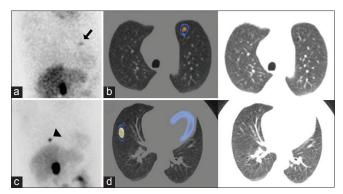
Rest single-photon emission computed tomography/computed tomography myocardial perfusion scintigraphy images showed a focal ^{99m}Tc-sestamibi accumulation in the anterior segment of the left upper lobe without any pulmonary pathology (arrow in [a] rest raw data image; [b] corresponding fusion lung window rest single-photon emission computed tomography/computed tomography and lung window computed tomography images). Stress single-photon emission computed tomography myocardial perfusion scintigraphy images revealed disappearance of the focal activity accumulation in the left lung and a focal uptake in the lateral segment of the right middle lobe with no pulmonary pathology (arrowhead in [c], stress raw data image; [d] fusion lung window single-photon emission computed tomography/computed tomography and corresponding lung window computed tomography)
